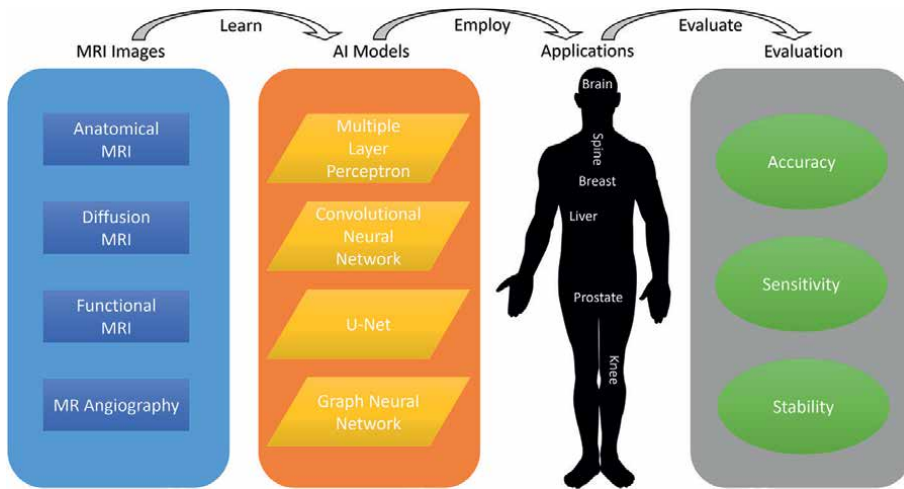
Organization. We first review MRI images. Next, we introduce common AI models that have been applied to learn those MRI images. Then, we investigate MRI applications that employ AI models. Finally, we discuss the evaluation metrics that are proposed to evaluate how well these AI models are.
